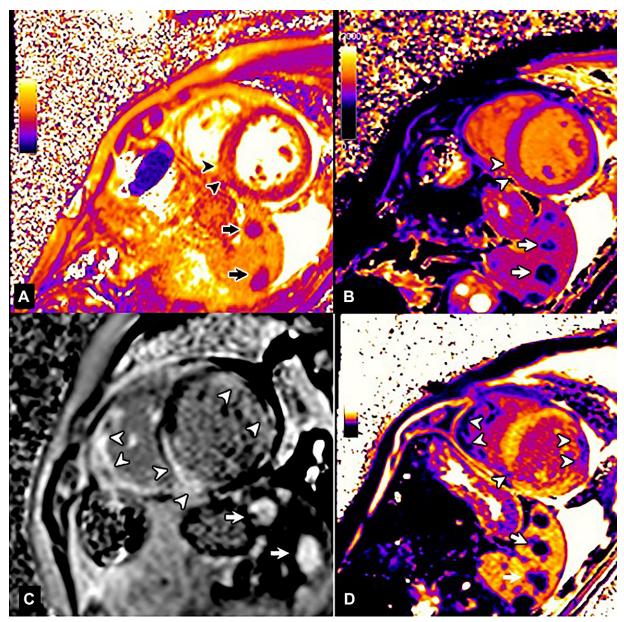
A 75-year-old man presented with heart failure, reduced left ventricular ejection fraction, and second-degree atrioventricular block at MRI. (A) Short-axis T2 map shows hyperintensity in the left inferoseptal myocardial wall (arrowheads) and hypointense nodules in the spleen (arrows) compared with healthy parenchyma. (B) T1 map at the same location shows there is blurred hyperintensity of the right ventricular septal insertion (arrowheads) and hypointense nodules in the spleen (arrows). (C) Postgadolinium delayed contrast-enhanced phase-sensitive inversion-recovery image shows multiple areas of late gadolinium enhancement in the right and left ventricles (arrowheads) and enhancing splenic nodules (arrows). (D) Color-coded T1 map after contrast media administration shows hypointensity at the same level of myocardial and splenic lesions (arrowheads and arrows, respectively).
